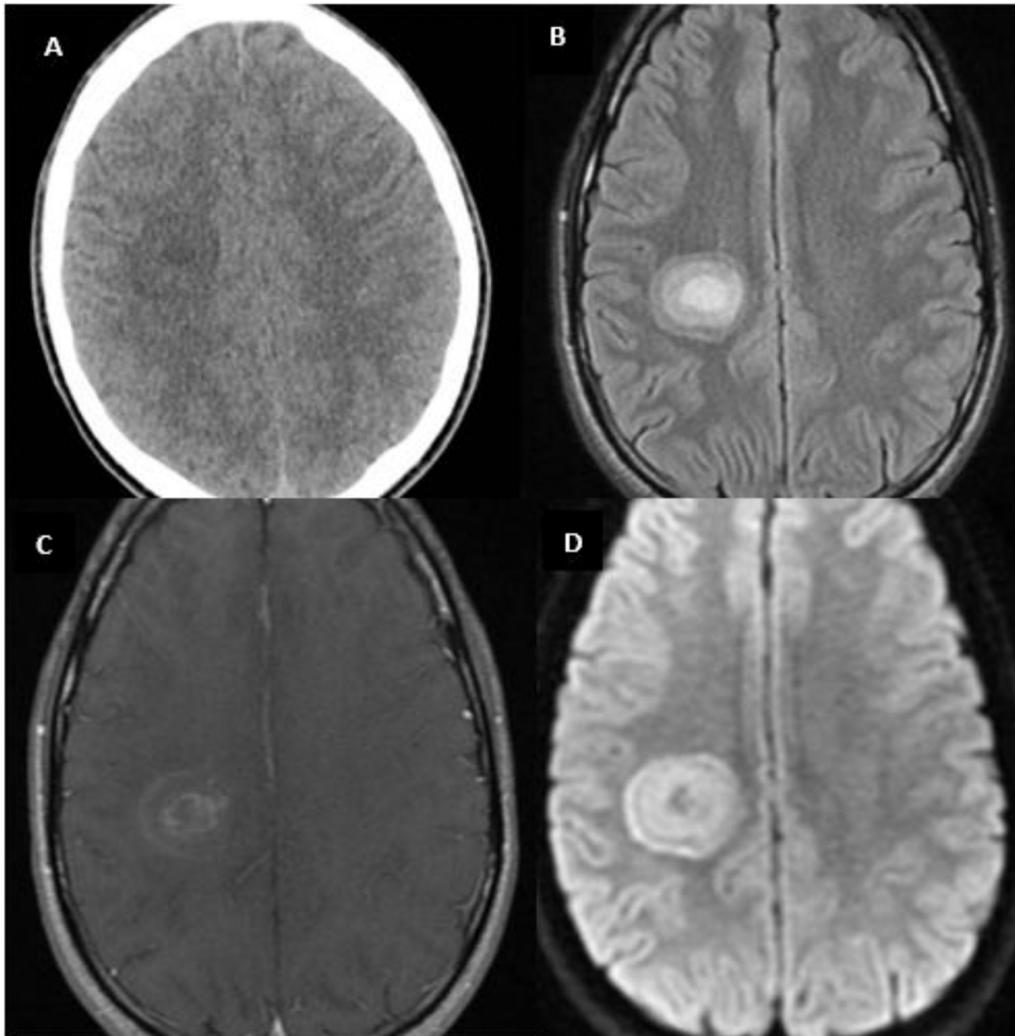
(A) Computed tomography of the head without contrast showing targetoid, mass-like 2.8-cm lesion in the right centrum semiovale. Magnetic resonance fluid-attenuated inversion recovery (B), postcontrast (C), and diffusion-weighted imagings (D) showing T2-hyperintense supratentorial white matter lesion with incomplete ringlike enhancement and restriction.
